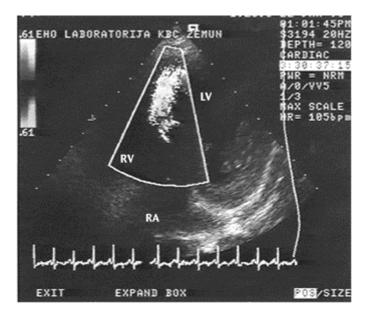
Ventricular septal rupture. In modified apical four-chamber view, color Doppler reveals abnormal jet
